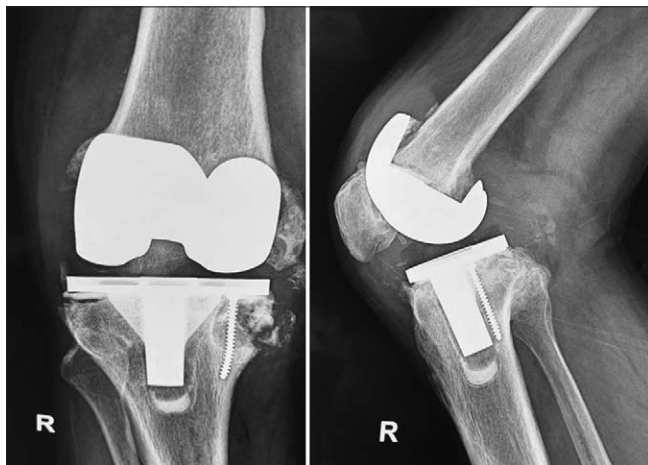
Preoperative radiographs showing extensive lysis and collapse of knee prosthesis
